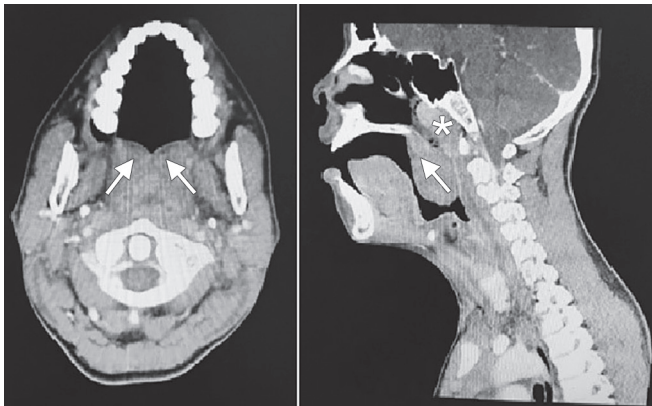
Contrast-enhanced computed tomography scan of neck revealed adenoid (\*) and palatine tonsils hypertrophy (arrow)
